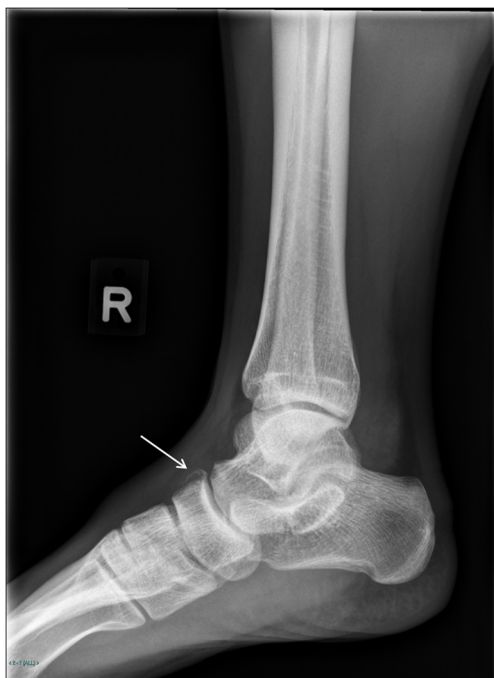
Lateral radiograph of the right ankle demonstrates a curvilinear bony fleck adjacent to the proximal dorsal cortex of the navicular consistent with an avulsion fracture of the navicular (arrow)
